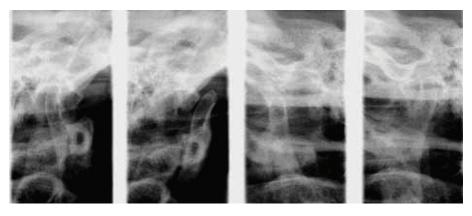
CT scan analysis of the temporomandibular joint (TMJ) of a patient born in 1968
